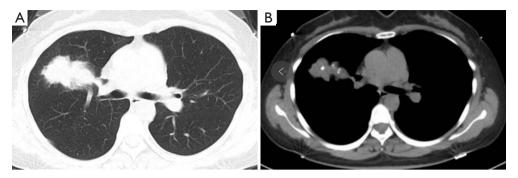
Chest CT image. (A) Chest CT lung window shows the soft tissue mass in the anterior segment of the right upper lobe, which is shallowly lobulated and burrs at the edges. (B) Chest CT longitudinal window shows the soft tissue mass in the anterior segment of the right upper lobe, with multiple calcifications.
